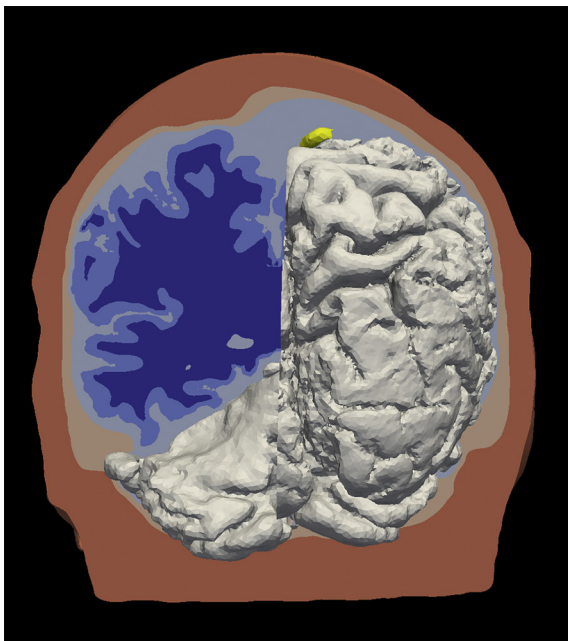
Individual 3D head model based on anatomical MRI. 3D volumetric mesh-model of an individual subject; left: cut through the different tissue classes: skin and subcutaneous tissue (pale red), skull (pale pink), cerebrospinal fluid (light blue), grey matter (light blue), white matter (dark blue); right: 3D surface of cortex (grey) and tumor (yellow).
